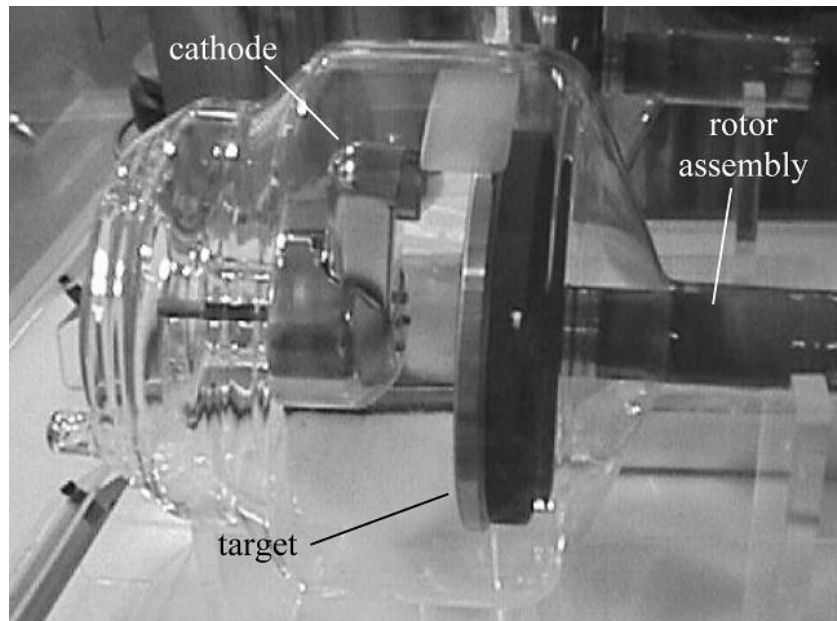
5 – Components of an X-ray tube. Reproduced from (5).
